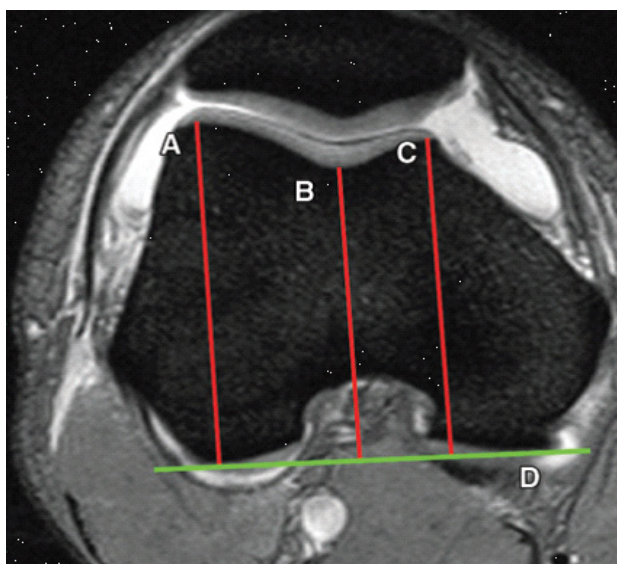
Trochlear depth assessed on axial fat-saturated T2-weighted MR images. A line drawn parallel to the posterior aspect of the femoral condyles serves as a reference line (line D). The lines drawn perpendicular to the reference line indicates the largest anteroposterior diameters of the lateral (line A) and medial (line C) trochlear facets and the deepest point of the sulcus (line B). Trochlear depth is calculated as follows: $(A + C/2) - B$. A trochlear depth of 3 mm or less is assumed to indicate dysplasia.
